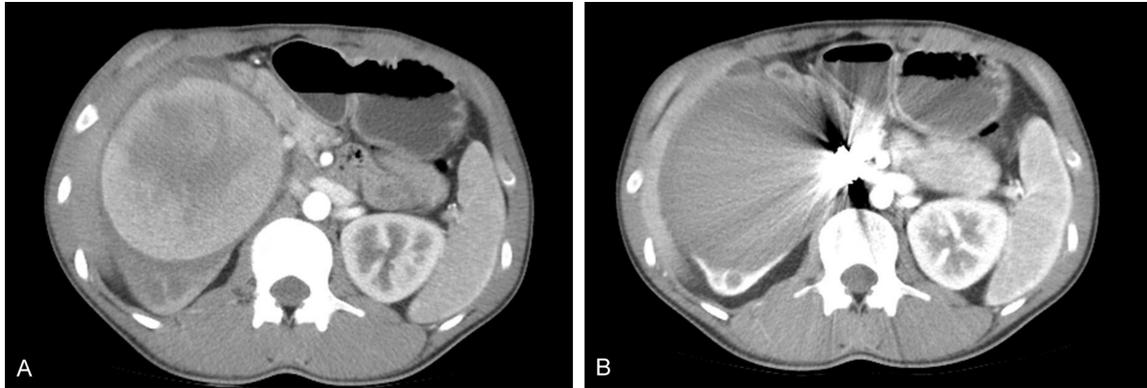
A and B. CTA performed on two months after operation exhibited an increased perfusion of the right kidney, while the RAA remained without significant enhancement.
